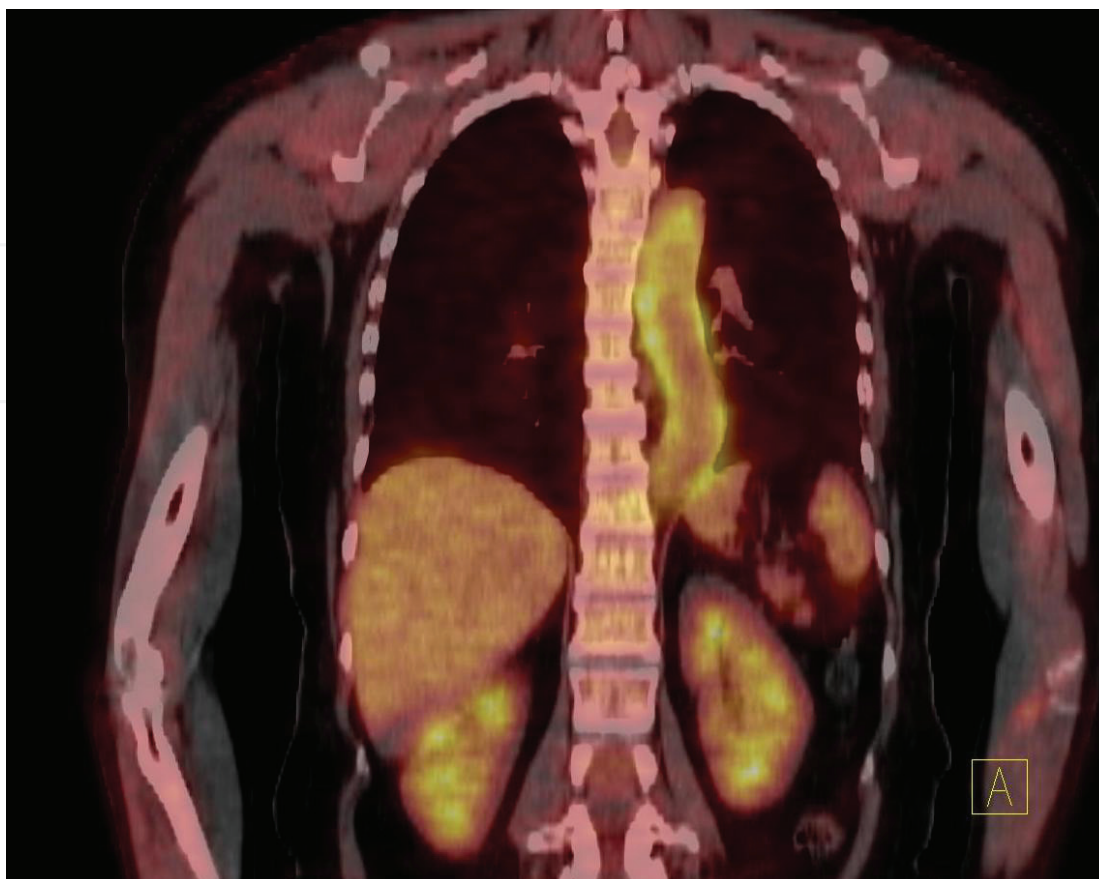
^{18}F -FDG PET-CT in patient with RA shows increased accumulation of the tracer in the wall of the aorta.
